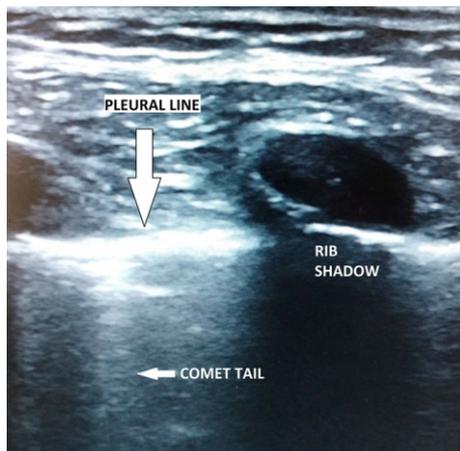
Ultrasound image of normal lung
